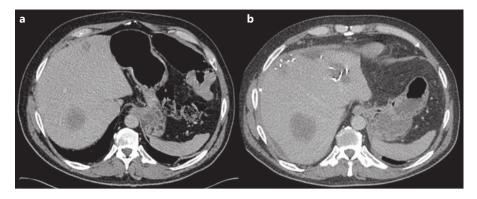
Staged hepatic resection. a Demonstrates a patient with bilobar metastases from a colonic cancer. The residual FLR is small and multiple other metastases are present elsewhere in the liver (not shown). b Demonstrates the CT appearance 4 weeks after initial resection. During the initial resection, multiple metastasectomies were performed in the left lobe to ensure that it was
